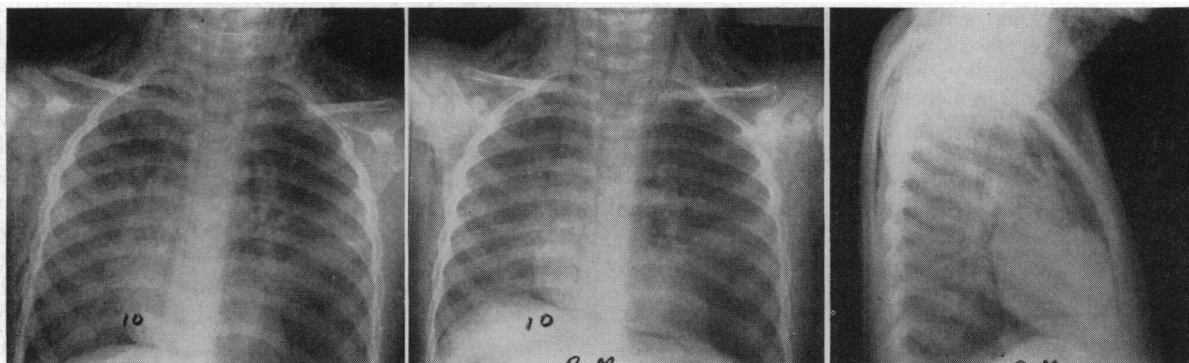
(Case 1).—X-ray films taken on admission to the hospital. *Left:* Film taken after inspiration shows an infiltrate in the left mid-lung field, hyperaeration of the left lung and subcutaneous emphysema. *Center:* Film taken after expiration accentuates the conditions and shows that the left lung does not deflate as well as the right. *Right:* Lateral view shows the presence of mediastinal and subcutaneous emphysema.
